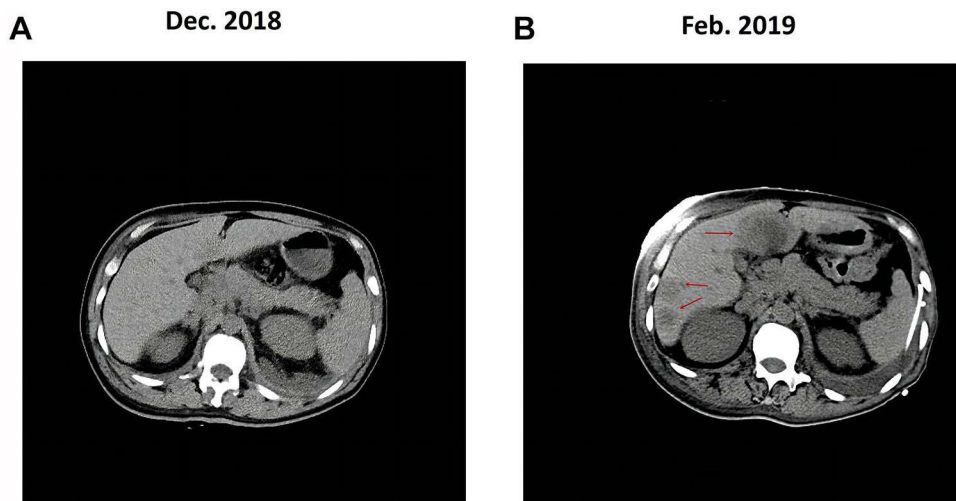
Images of liver computed tomography (CT) scans of the patient before (A) and after (B) crizotinib.
